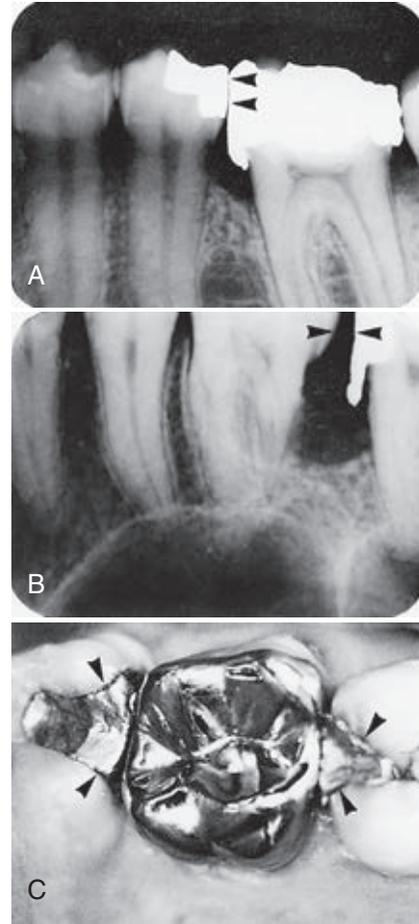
Poor anatomic restorative form. A, Radiograph of flat contact and amalgam gingival excess. B, Radiograph of restoration with amalgam gingival excess and absence of contact resulting in trauma to supporting tissue. C, Poor occlusal margins.
